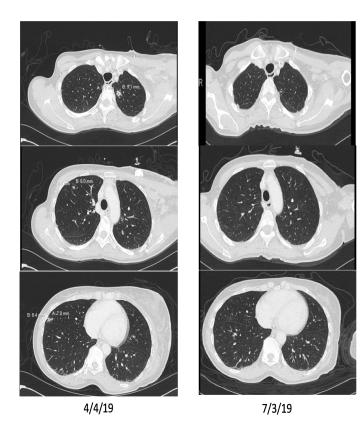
CT scans of the infiltrative disease in the left breast/axilla and pulmonary nodules.
